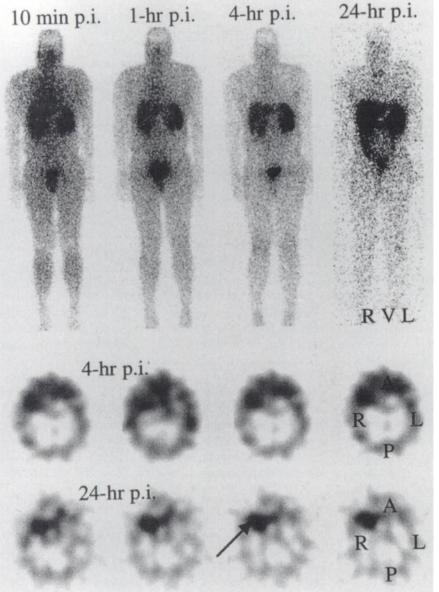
(Top row) Planar whole-body images at 10 min and 1, 4 and 24 h in anterior projection. (Bottom rows) Corresponding transverse SPECT slices at 4 and 24 h. Note focal tracer uptake in area of right sphenoid bone at 24 h, indicating meningioma tissue in patient and negative SRS at 4 h in planar whole-body image as well as in SPECT slices. p.i. = postinjection.
